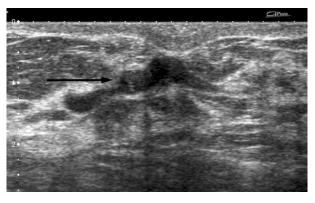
Asymptomatic 53-year-old woman. Sonogram shows a 9mm intraductal mass (arrow) with an oval shape and microlobulated margins, categorized as BI-RADS 4a. There was no abnormal vascularity on power Doppler interrogation (not shown). Core needle biopsy and surgical excision showed intraductal papilloma.
